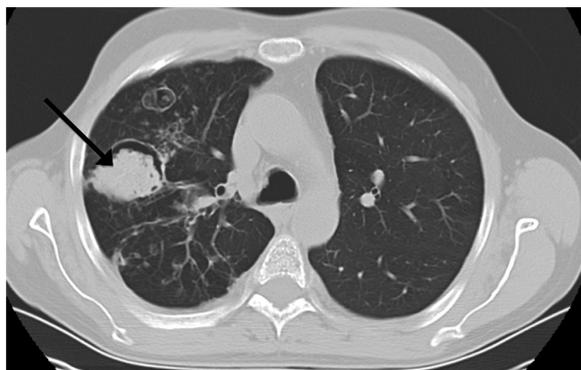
Chest CT of a 48 year old with AD-HIES showing bronchiectasis, and a pneumatocele with an Aspergilloma (arrow).
